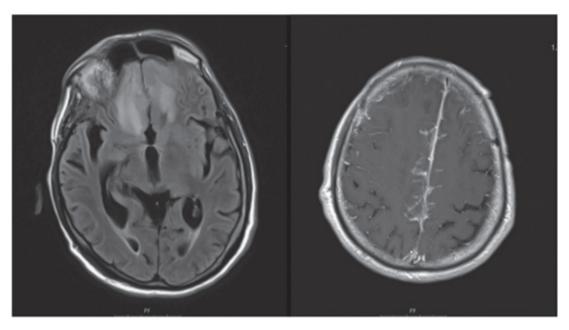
(a) Axial FLAIR images showing brain parenchyma edema bilaterally in frontal regions; (b) axial T1W postcontrast images showing leptomeningeal contrast enhancement. Intraparenchymal changes show no contrast enhancement.
